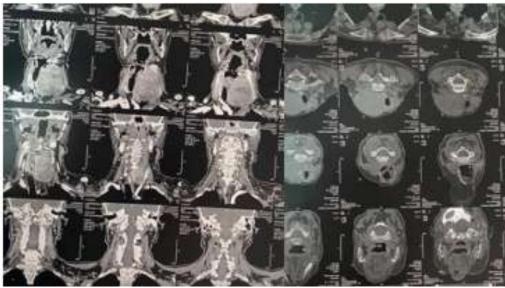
Cervio-faciall CT scan showing thickening of the mucosa of the right maxillary sinus with a smallresidue at the level of the upper orifice of the left lacrymo-nasal duct and behind the properbone of the left nosewithout cervical lymphadenopathy or a pulmonary metastasis.
